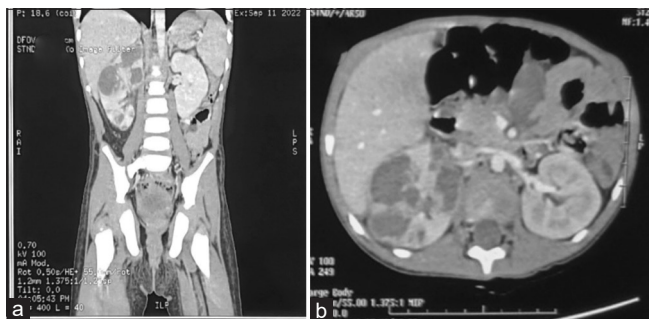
Contrast-enhanced computed tomography abdomen (a) coronal view (b) axial view showing acute pyelonephritis with multiple intraparenchymal and subcapsular collections with subtle peripheral enhancement, suggesting early abscess formation largest measuring 3 cm × 2.4 cm × 3 cm
